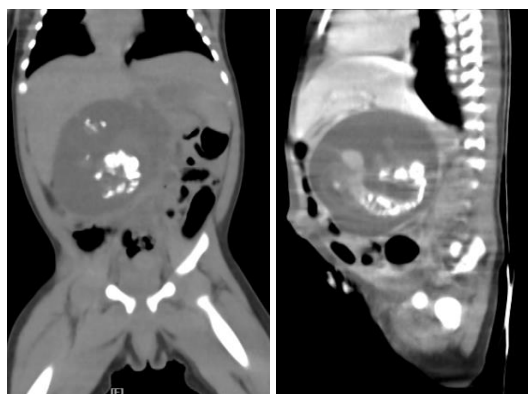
CT-scan of the abdomen with contrast revealed a heterogeneous mass of a mixture of cystic and solid accompanied by calcification in the form of vertebrae and extremities in the upper right abdomen (size \pm 5.6x6x6cm)
